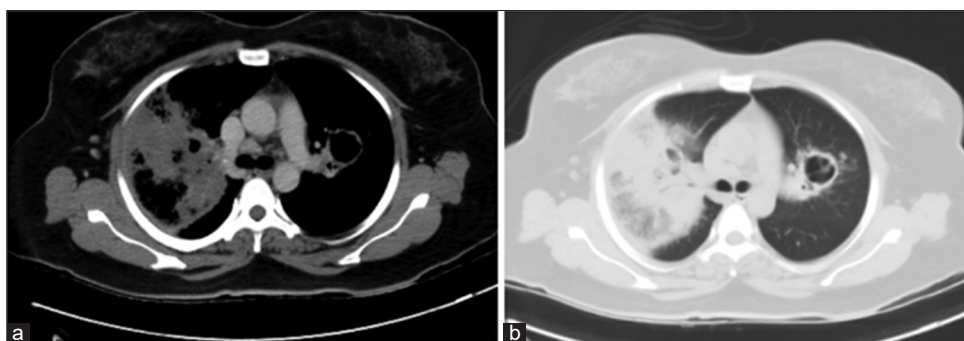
Contrast-enhanced computed tomography thorax [mediastinal window (a) lung window (b)] showing the right upper lobe necrotising pneumonia with cavity in the left upper lobe
